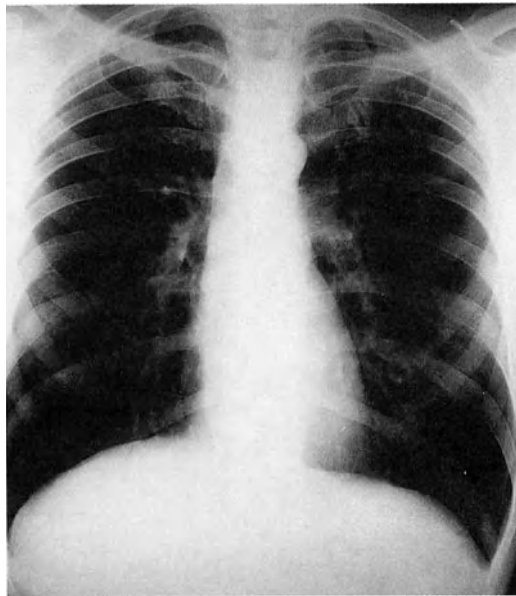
Chest radiograph in achalasia showing no air in the gastric fundus
